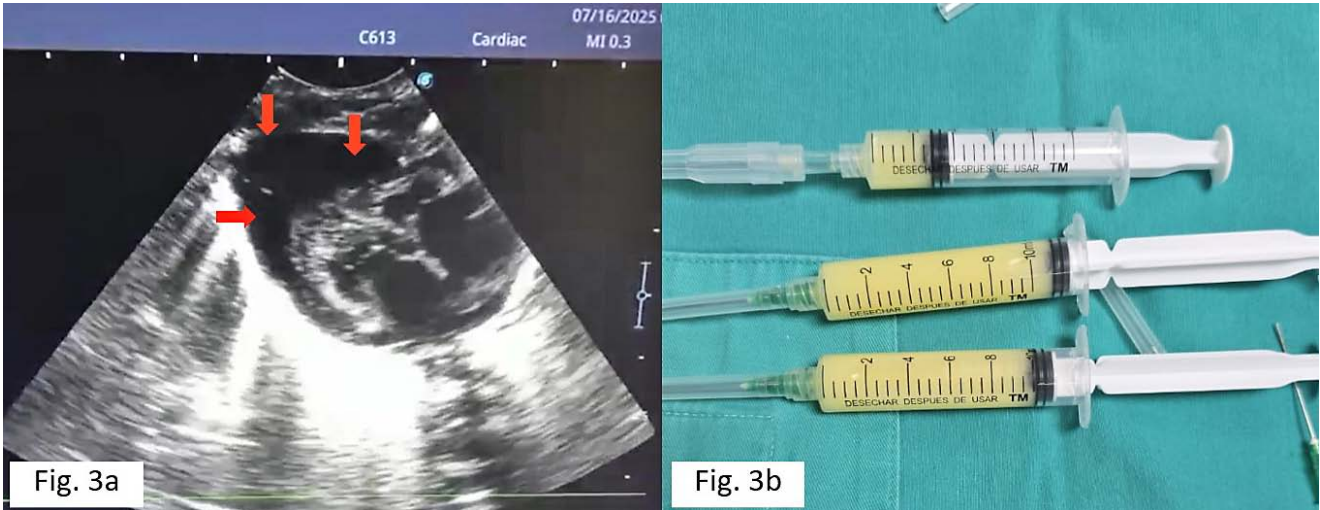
3a. Echocardiography revealed a large pericardial effusion. 3b. An ultrasound-guided pericardial puncture was performed, draining ~21 mL of milky fluid.
